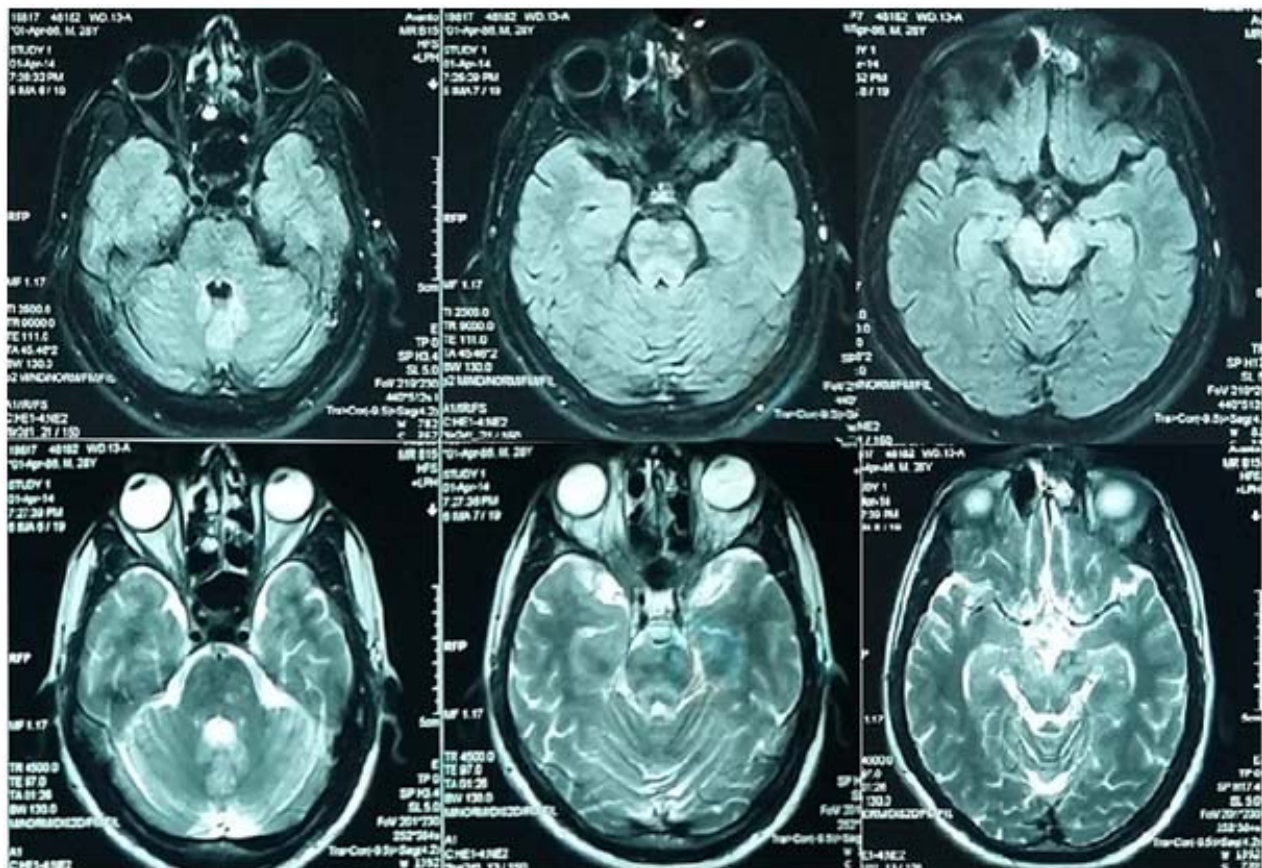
MRI. Multiple focal hyperintensities in fluid attenuated inversion recovery (FLAIR) (top row) and T2 weighted (bottom row) images.
